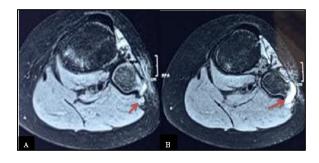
MRI pictures showing osteochondroma (A) tenting of the common peroneal nerve due to tumor (arrow). (B) cartilage cap (arrow).
